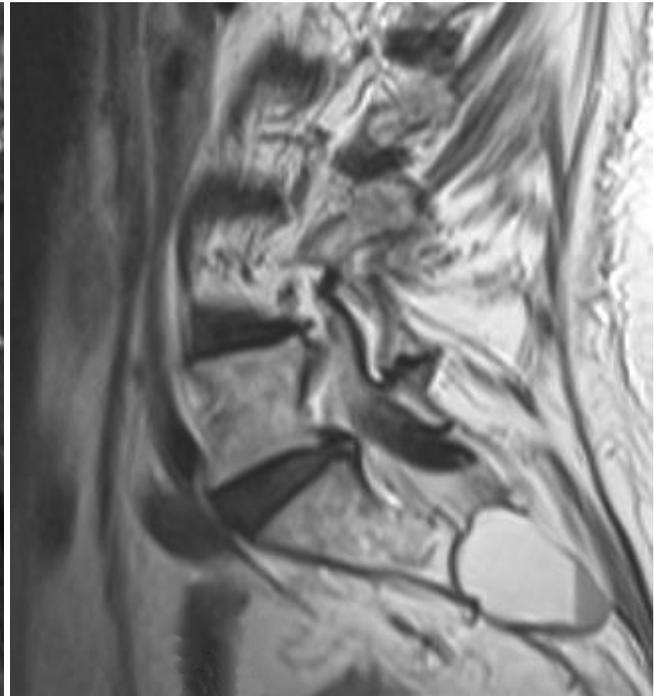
Post-procedure MRI showing the blood level at the meningocele's bottom.
